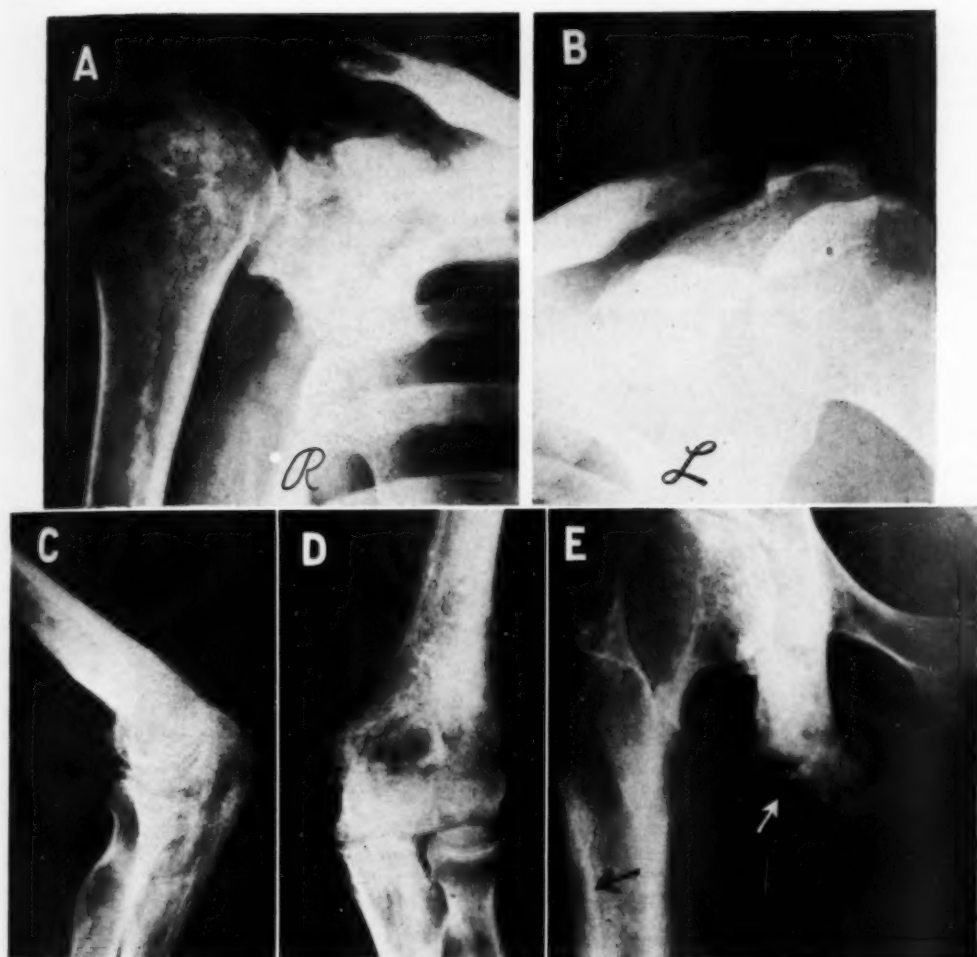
Case 4: The roentgenograms A and B reveal a marked destructive process involving the lateral aspect of the right clavicle, lateral aspect of the left clavicle, and the right scapula. The medial aspect of the right clavicle is involved as well. The right shoulder region (A) shows a severe osteolytic process involving the clavicle, humerus, and scapula. There is very little evidence of periosteal proliferation but marked calcification is present in the soft tissues. Note the punched-out areas in the right humerus. The ribs are essentially normal. The right elbow region (C and D) shows destruction with also some periosteal proliferation.
